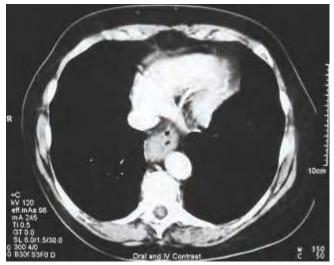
Computed tomography scan showing a primary tumour of the lower oesophagus.
